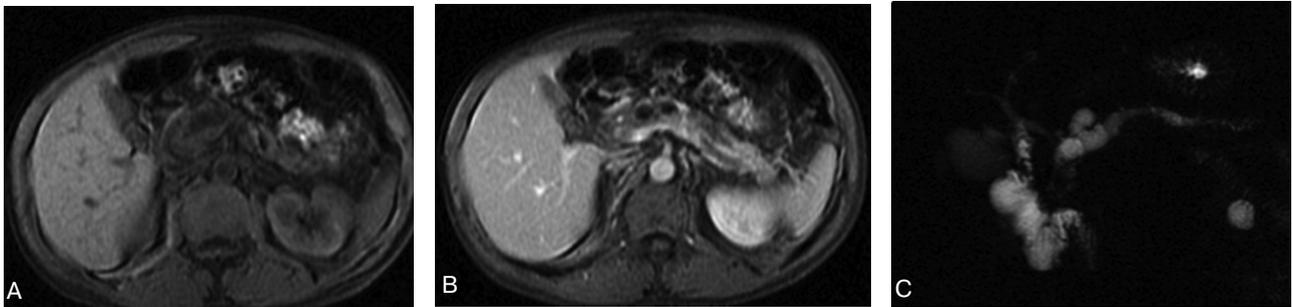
MRI of mixed type intraductal papillary mucinous neoplasm at the junction of the head and body of the pancreas. A. T2-weighted MR image shows dilatation of the main pancreatic duct and of a side branch. B. T1-weighted gadolinium enhanced image C. MR pancreatography image.
